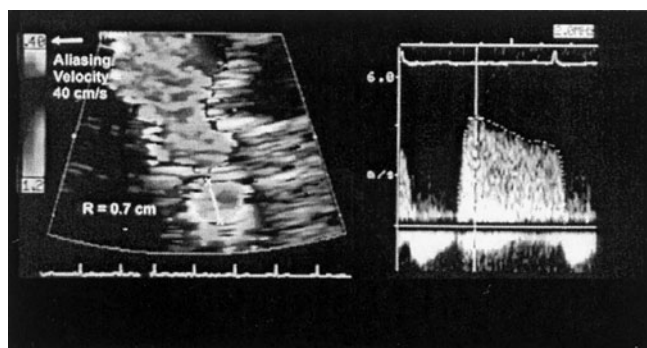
Quantitation of aortic regurgitation (AR) using the proximal isovelocity surface area (PISA) method. Note that the color baseline is shifted upward. (Left) Analysis of the flow convergence allows measurement of the regurgitant flow. (Right) AR velocity is measured using continuous-wave Doppler to calculate the regurgitant volume (RVol) as flow multiplied by the ratio of regurgitant time velocity integral (RTVI) to regurgitant velocity (RVel).
